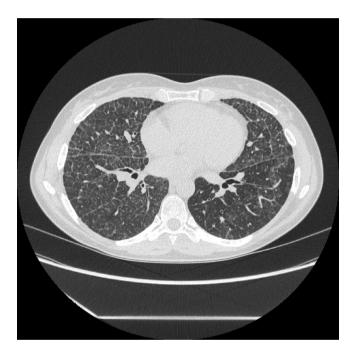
High-resolution computed tomography revealing ground-glass opacities and interlobular septal thickening.
